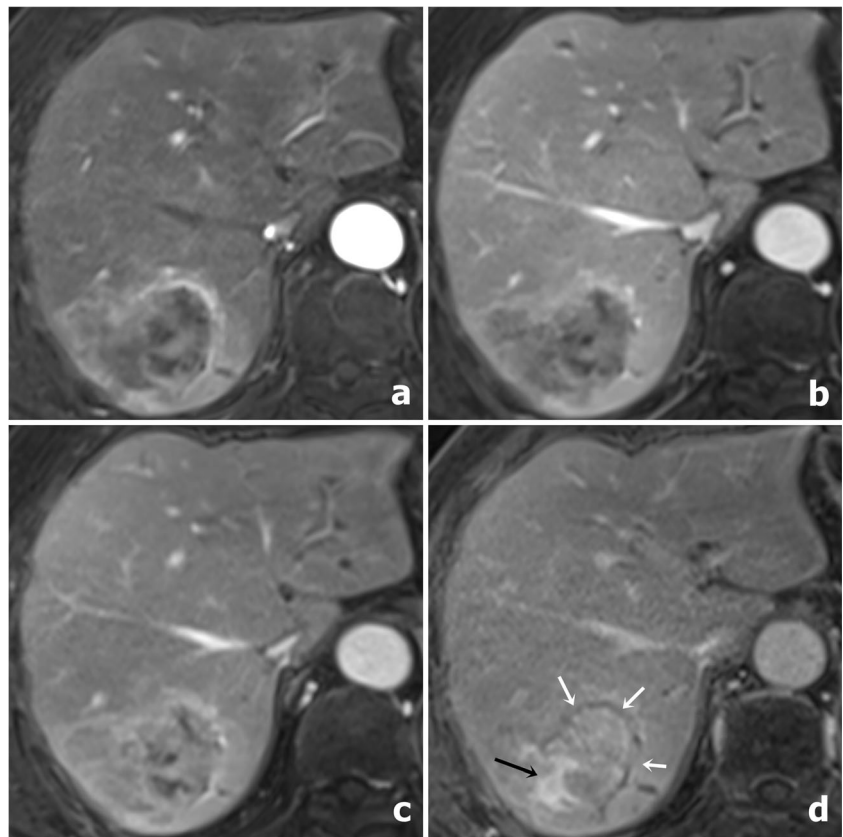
An intrahepatic cholangiocarcinoma in a 67-year-old man with B-viral liver cirrhosis; imaging features are prominently visible in the 15-min delayed phase of extracellular contrast agent-enhanced MRI. (a) A 4.5-cm mass with irregular rim-like arterial phase hyperenhancement is seen in the right posterior liver. (b and c) No specific imaging findings other than subtle progressive contrast enhancement are noted in the portal (b) and late dynamic (c) phases. (d) In the 15-min delayed-phase, peripheral washout appearance (white arrows) and delayed-phase central enhancement (black arrow), features that favour other hepatic malignancy over hepatocellular carcinoma, are visible
